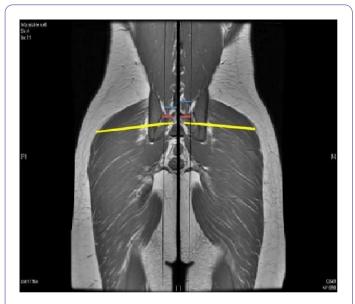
MRI coronal pelvic T1 image reflecting medial origin and widest lateral portion of gluteus maximus on both sides.
